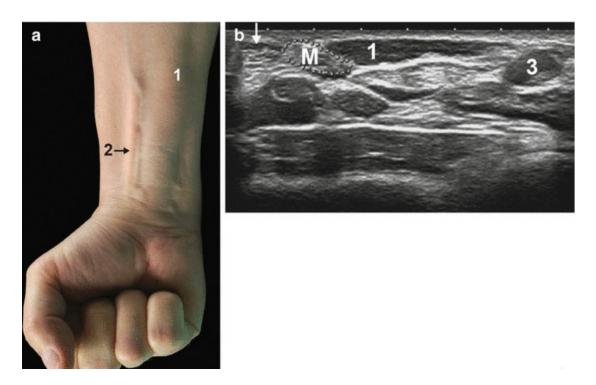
(a) Swelling in the palmar area of the wrist corresponding to a reversed palmaris longus muscle (1) next to the tendon of the flexor radialis carpi muscle (2). (b) Transverse ultrasound image of the distal ventral forearm shows a reversed palmaris longus muscle (1) close to the median nerve (M). The variant belly (1) is located between the distal tendon of the flexor radialis carpi muscle (arrow) and the radial artery (3)
